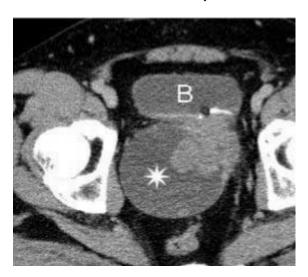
CT of the pelvis: Enhanced axial image
